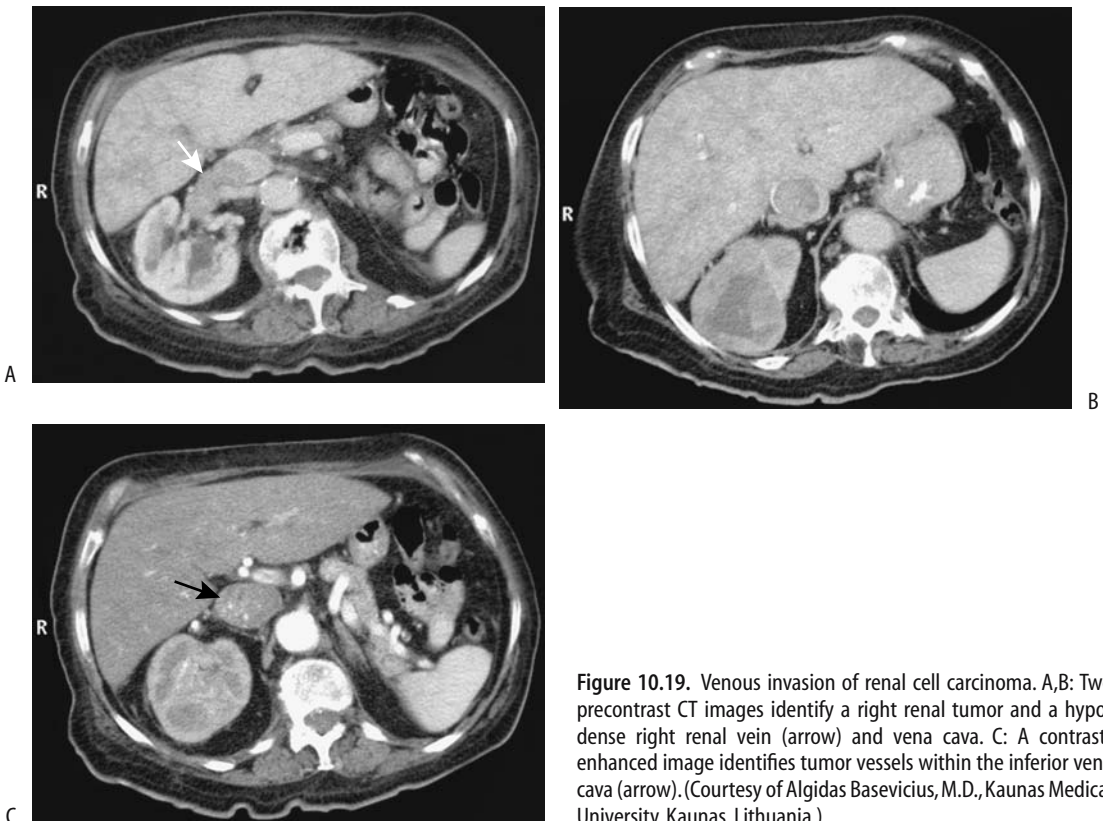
Venous invasion of renal cell carcinoma. A,B: Two precontrast CT images identify a right renal tumor and a hypodense right renal vein (arrow) and vena cava. C: A contrast-enhanced image identifies tumor vessels within the inferior vena cava (arrow). (Courtesy of Algidas Basevicius, M.D., Kaunas Medical University, Kaunas, Lithuania.)
